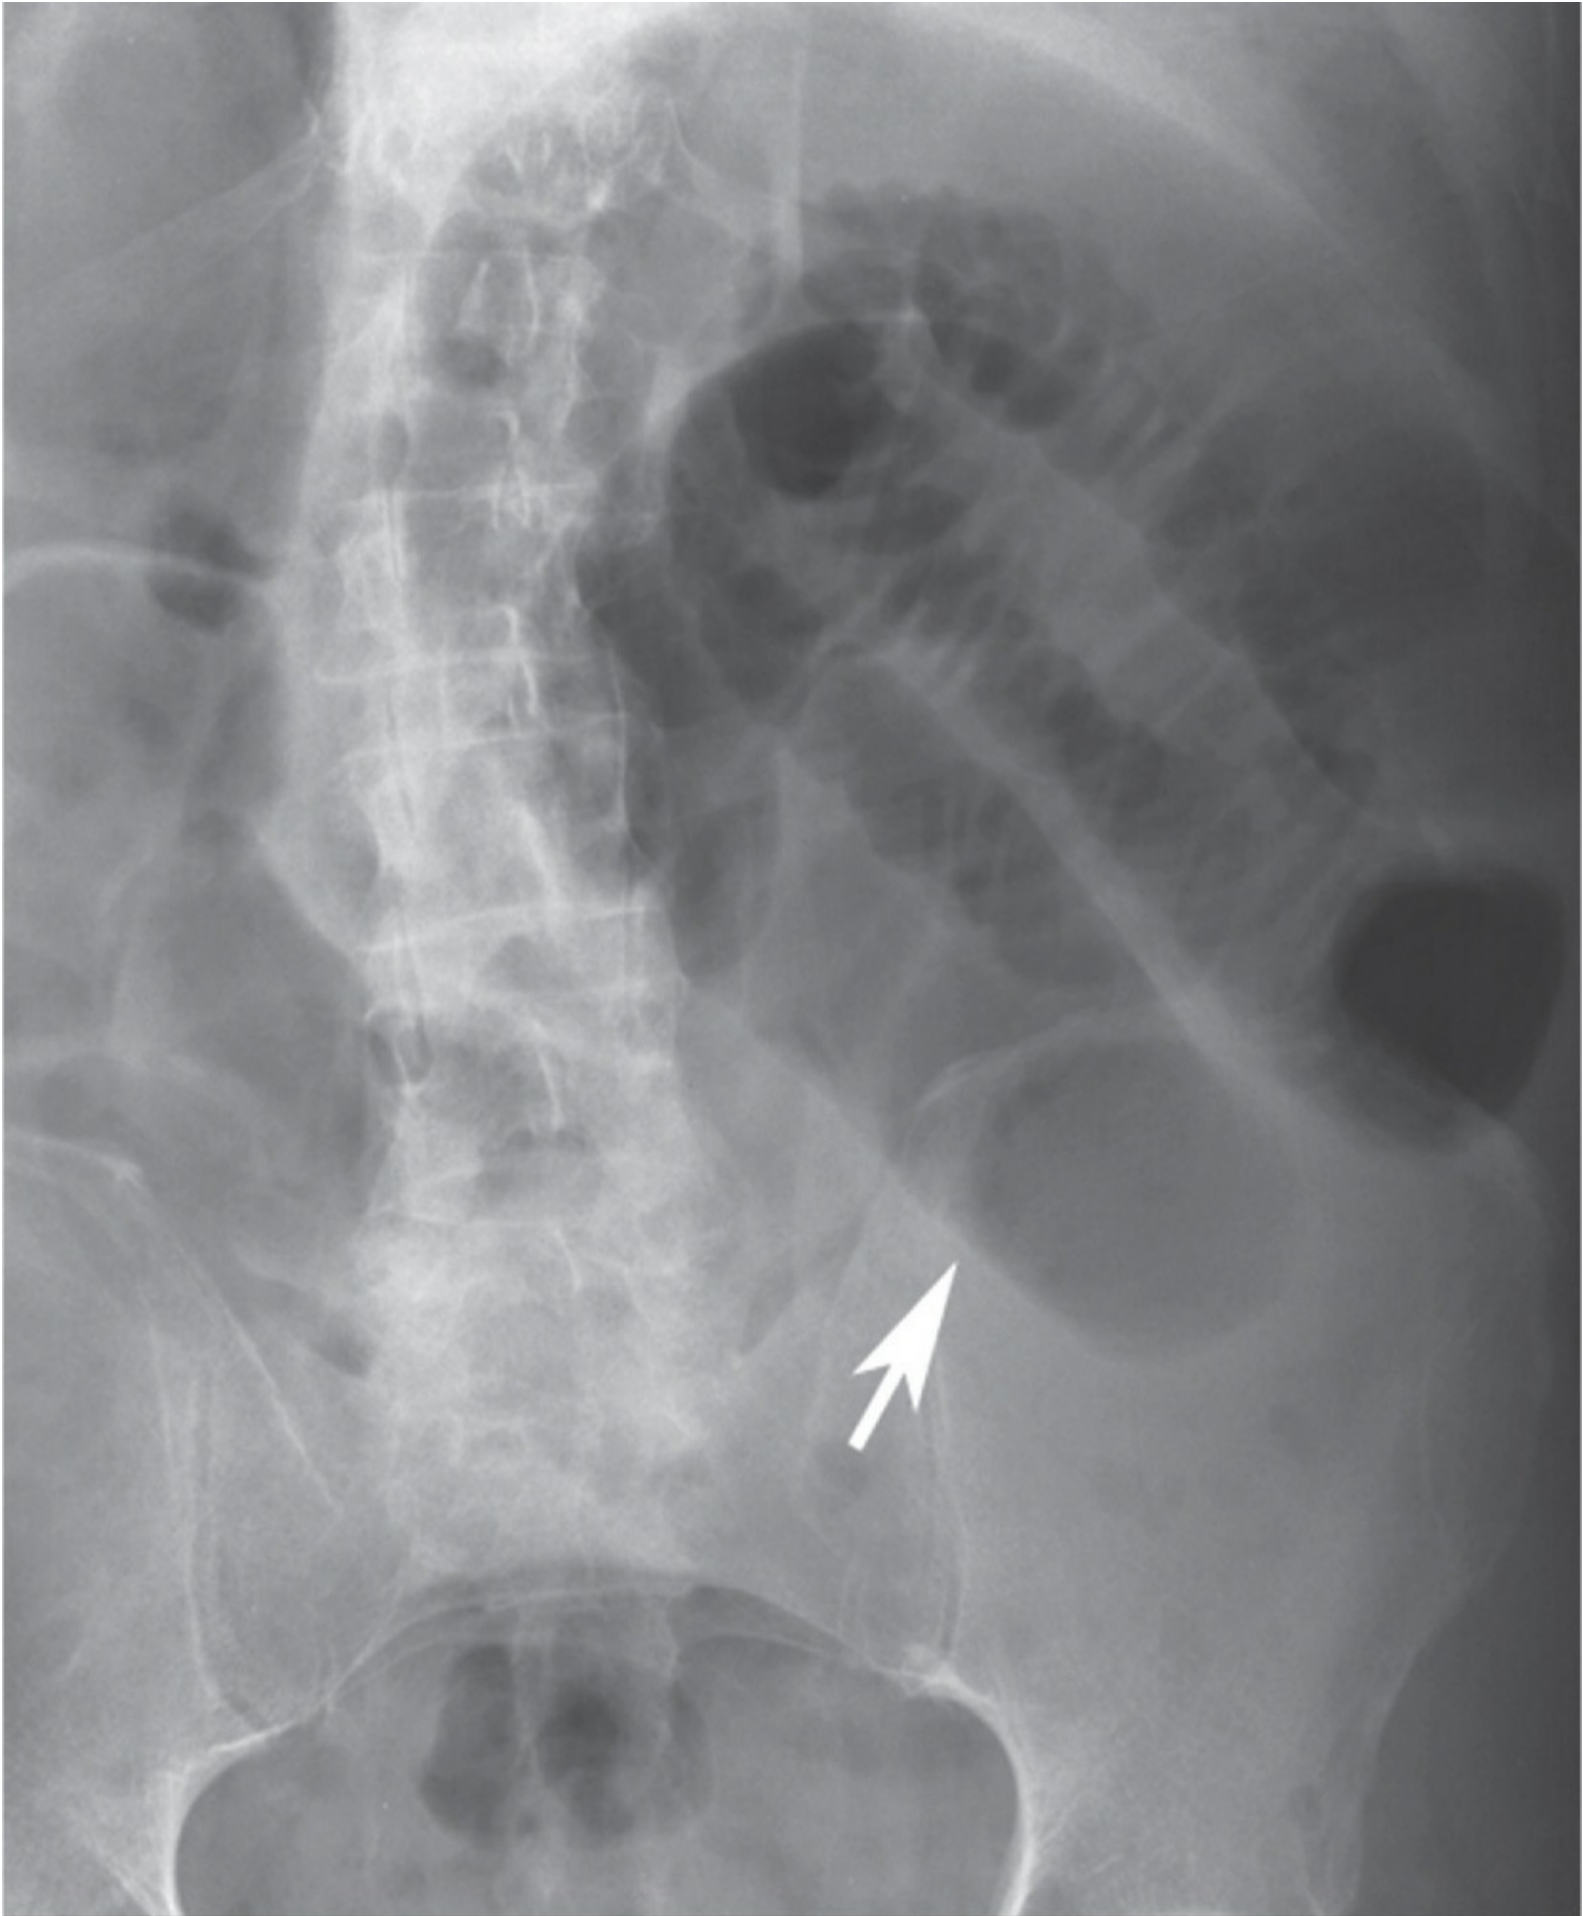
Small bowel obstruction. Abdominal radiograph image shows severe dilation of jejunal small bowel loops with acute transition (*arrow*). (Reproduced, with permission, from Morte KJ. State-of-the-art imaging of the gastrointestinal system. In: Greenberger NJ, Blumberg RS, Burakoff R, eds. *Current Diagnosis & Treatment: Gastroenterology, Hepatology, & Endoscopy*. 2nd ed. New York: McGraw-Hill; 2012.)
